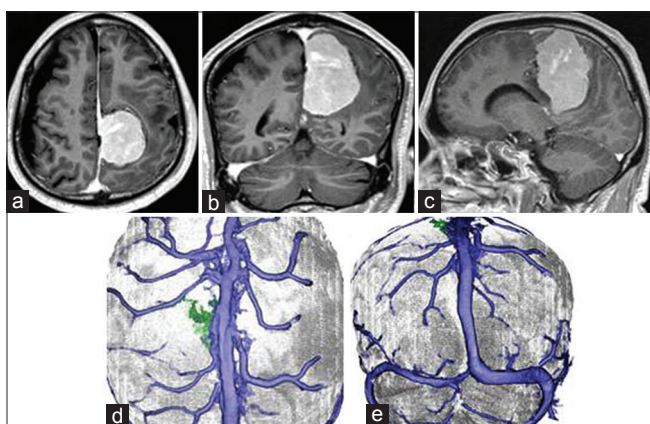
Case 1 – (a-c) Magnetic resonance images on admission showing an extra-axial tumor lesion of 6-cm diameter with dural attachment in the middle third of the falx, with homogeneous enhancement by contrast agent. (d and e) Three-dimensional computed tomography venograms revealing several bridging veins including the rolandic vein passing adjacent to the tumor (d). No bridging veins flowed into the superior sagittal sinus in the occipital lobe (e)
